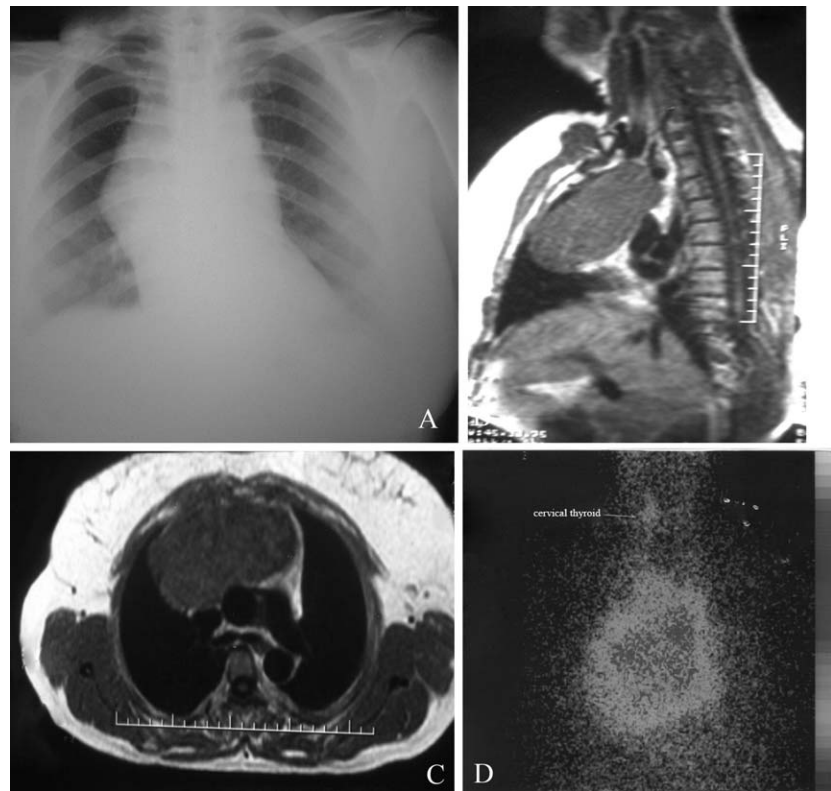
(A) Chest X-ray showing enlarged upper mediastinum due to substernal goiter. (B) Sagittal plain CT scan showing substernal goiter in the anterior mediastinum. (C) Computed tomography showed that the substernal thyroid mass extends distal to the tracheal bifurcation. (D) Thyroid scintigraphy showing large intrathoracic goiter.
